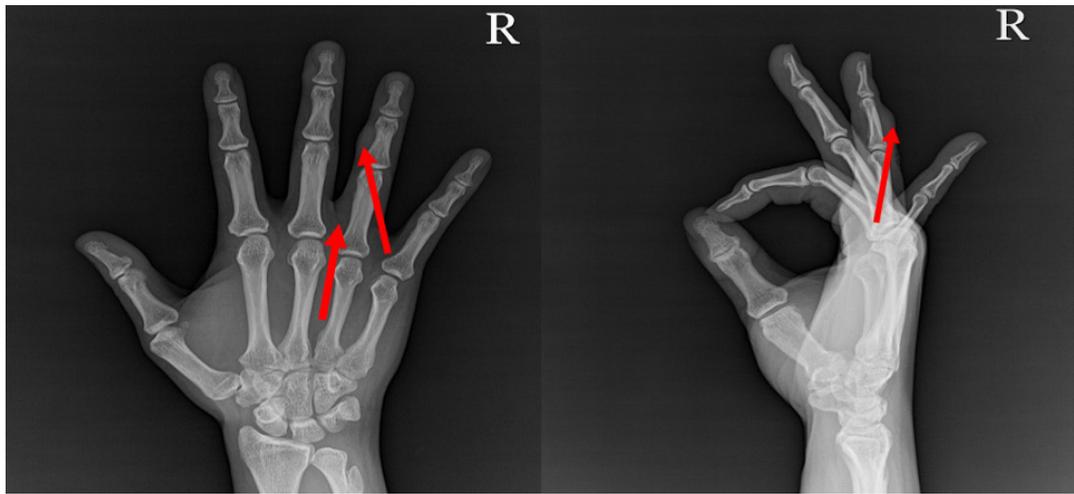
The anteroposterior and lateral radiograph of right hand. Shows noncalcified soft tissue nodular thickening with similar density on dorsal surface of right ring finger (Red arrows). The volar masses are too small and not appear to protrude on an x-ray.
